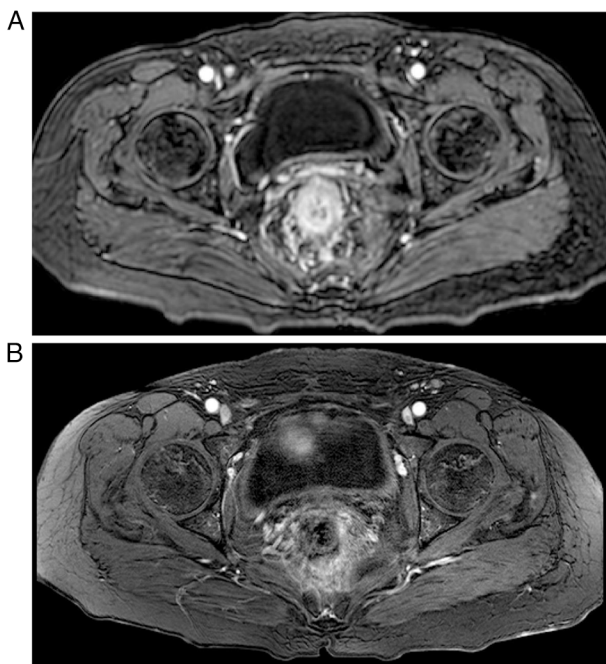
T1-weighted magnetic resonance images. (A) Rectum wall thickening before treatment. (B) Thickness of the rectum wall improved after two cycles of treatment.
